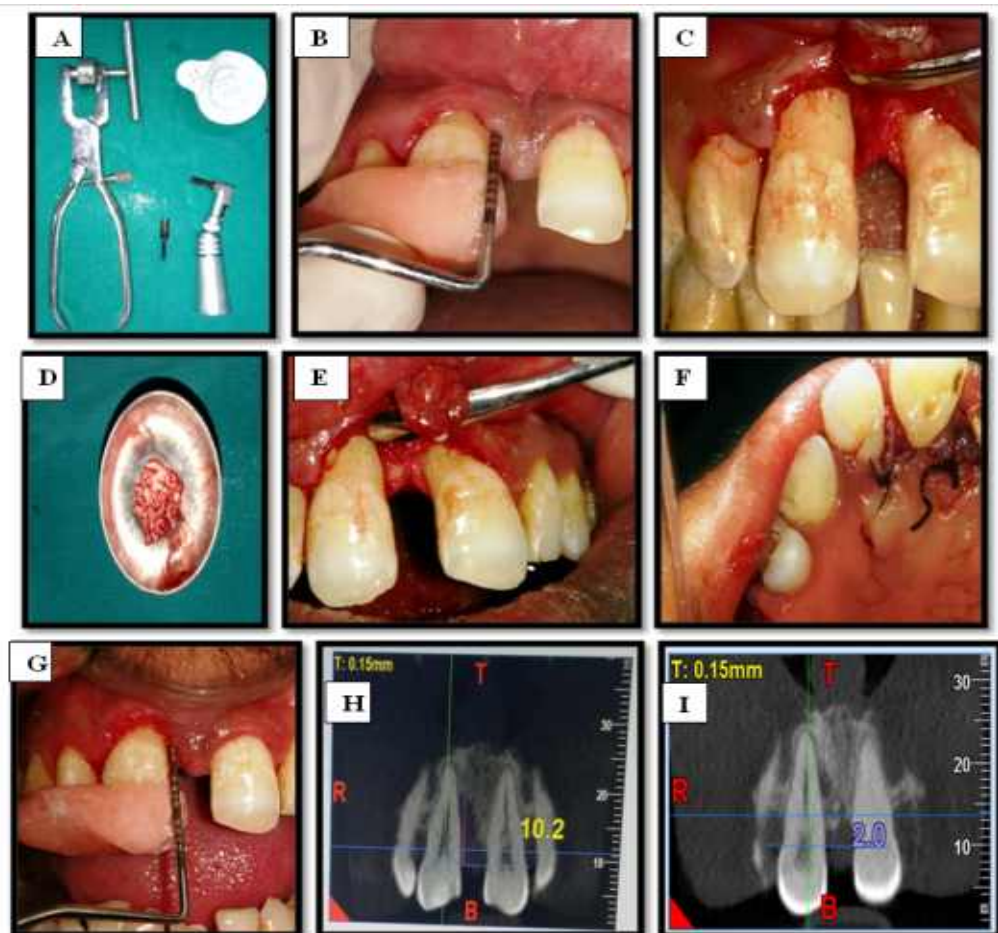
Armamentarium and Surgical Procedure (test site) A. Contrangle Hand Piece with Trephine Bur and Bone Mill B. Pocket probing depth and RCAL at baseline C. Debridement of the defect D. Bone graft procured from extracted site E. Placement of the bone graft F. Sutures placed G. Pocket probing depth and relative clinical attachment level at 6 months H. CBCT at Baseline I. CBCT at 6 Months.
